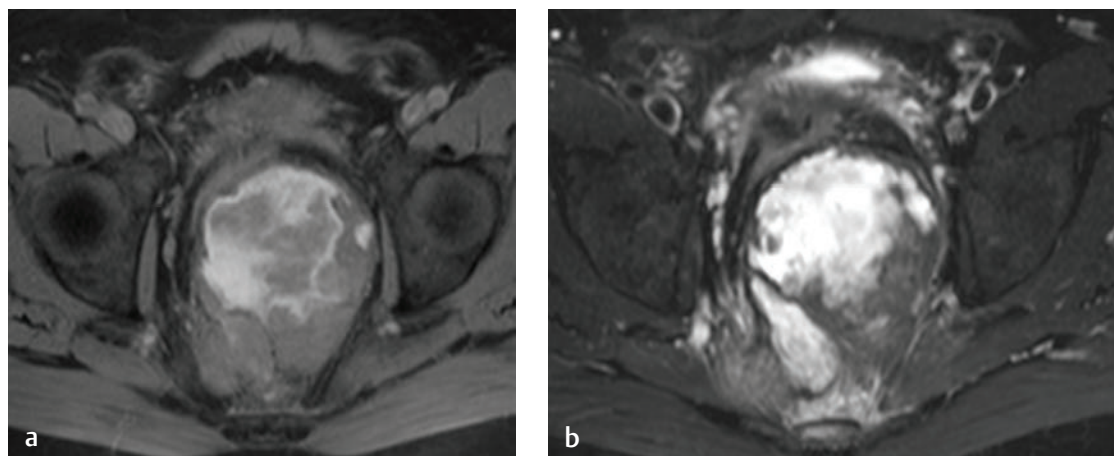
Sacral giant cell tumor. This expansile lesion shows heterogeneous enhancement on (a) a coronal postcontrast T1-weighted image and high signal intensity on (b) an axial fat-suppressed T2-weighted image.
